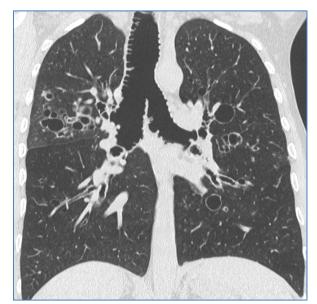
Coronal Chest CT scan objectifying diverticular tracheobronchomegaly.
